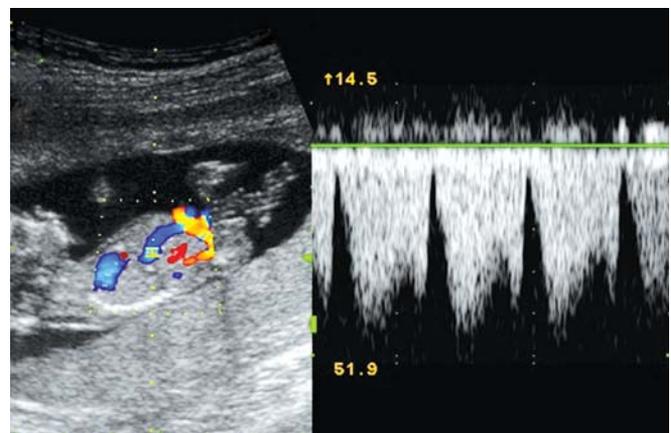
Normal Doppler blood flow in the first trimester fetus—orthograde blood flow during whole cardiocycle
